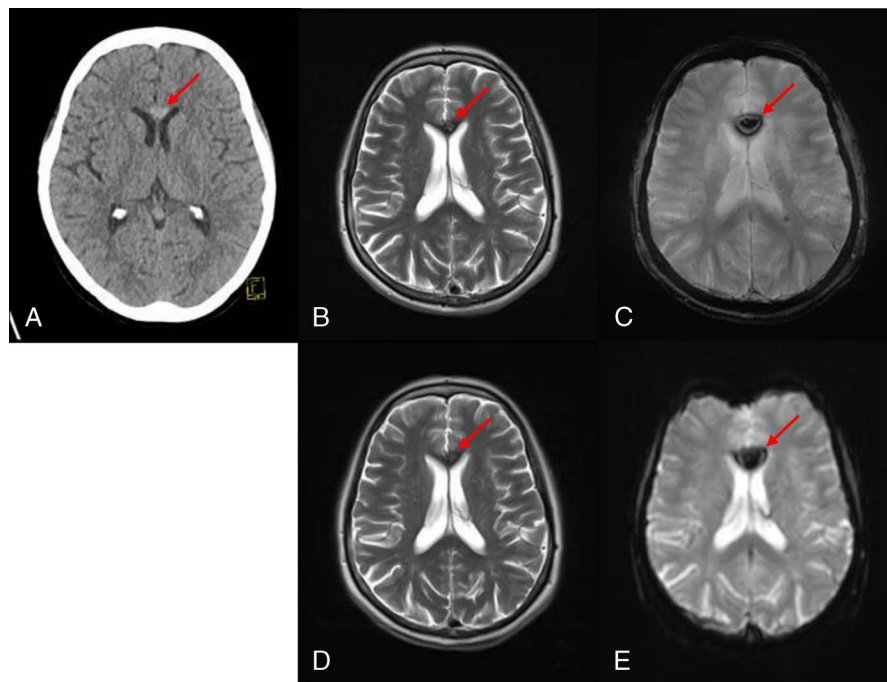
Incidental cavernoma (genu of the corpus callosum). Axial noncontrast head CT (A), axial T2 TSE (B and D), axial T2* (C and E) from the standard-length protocol (top row) and ultrafast-MRI (bottom row) of a 62-year-old woman reporting visual disturbance of the right eye for about 15 to 30 minutes. Neither CT nor MRI showed a correlate for the symptoms. However, noncontrast CT demonstrated a hyperdense lesion in the genu of the corpus callosum (A, arrow) not in line with acute hemorrhage. Based on the subsequently acquired MRI, this lesion could be diagnosed as incidental cavernoma, demonstrating the typical low to intermediate T2 signal (B and D, arrow) and susceptibility artifacts (B–E, arrow). No developmental venous anomaly. This is a classic case in which the patient would have been referred to an outpatient MRI unit for further diagnostic workup of the hyperdense lesion a few days later. However, ultrafast-MRI was able to deliver the final diagnosis during initial presentation to the emergency department in a one-stop-shop manner.
